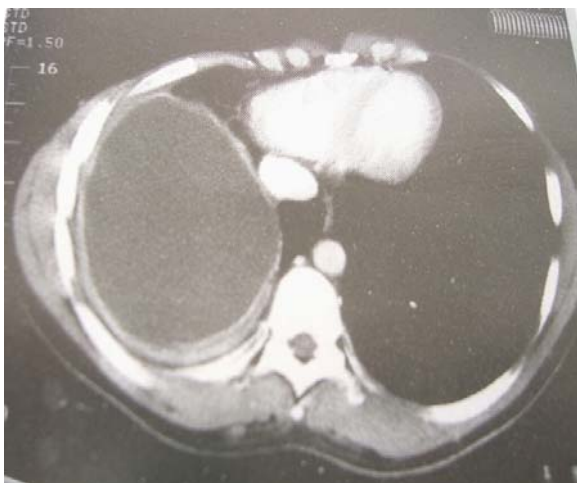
CT of the Empyema of the Right Chest
